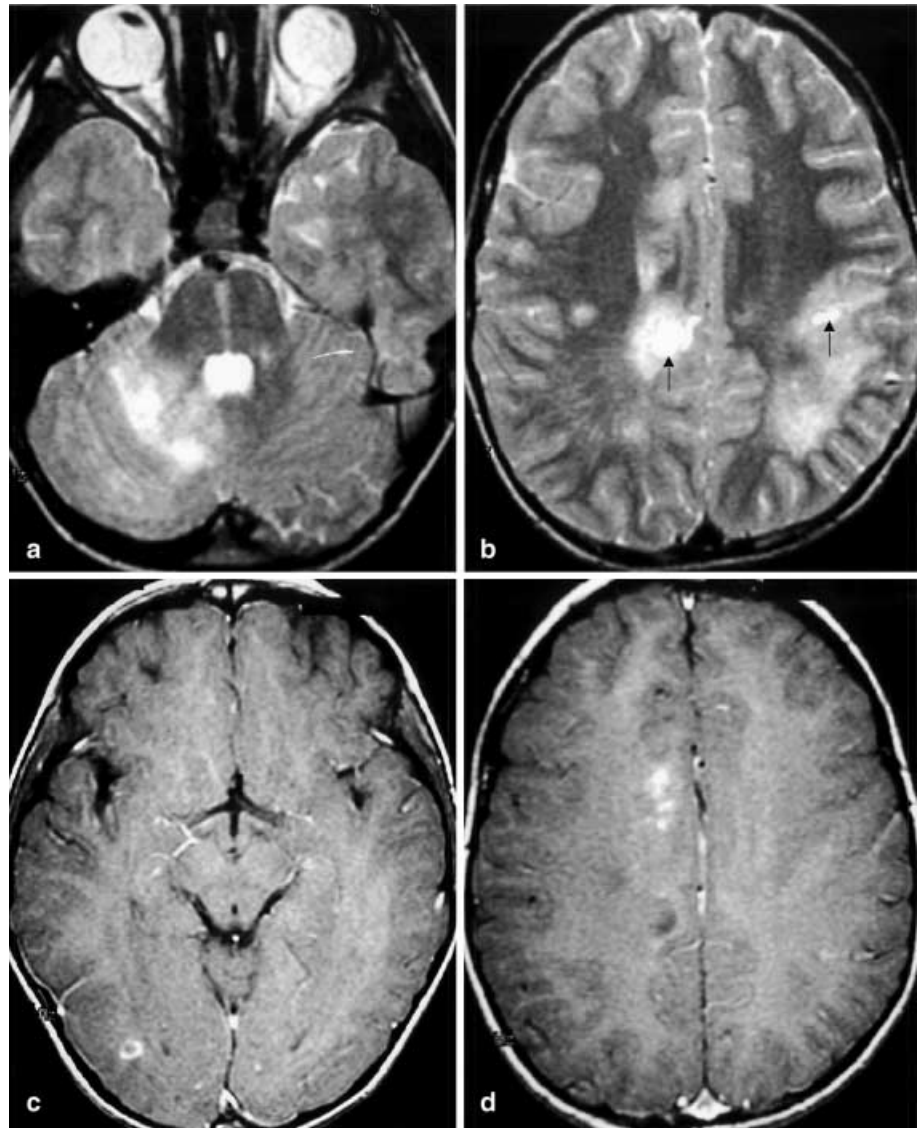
Patient 1. An 18-month-old girl who presented with status epilepticus 1 day after vaccination (measles, mumps and rubella). FSE T2-W axial MRI performed 18 days after presentation shows diffuse hyperintensity in the deep and subcortical white matter with sparing of the capsular fibres (*arrows*)
